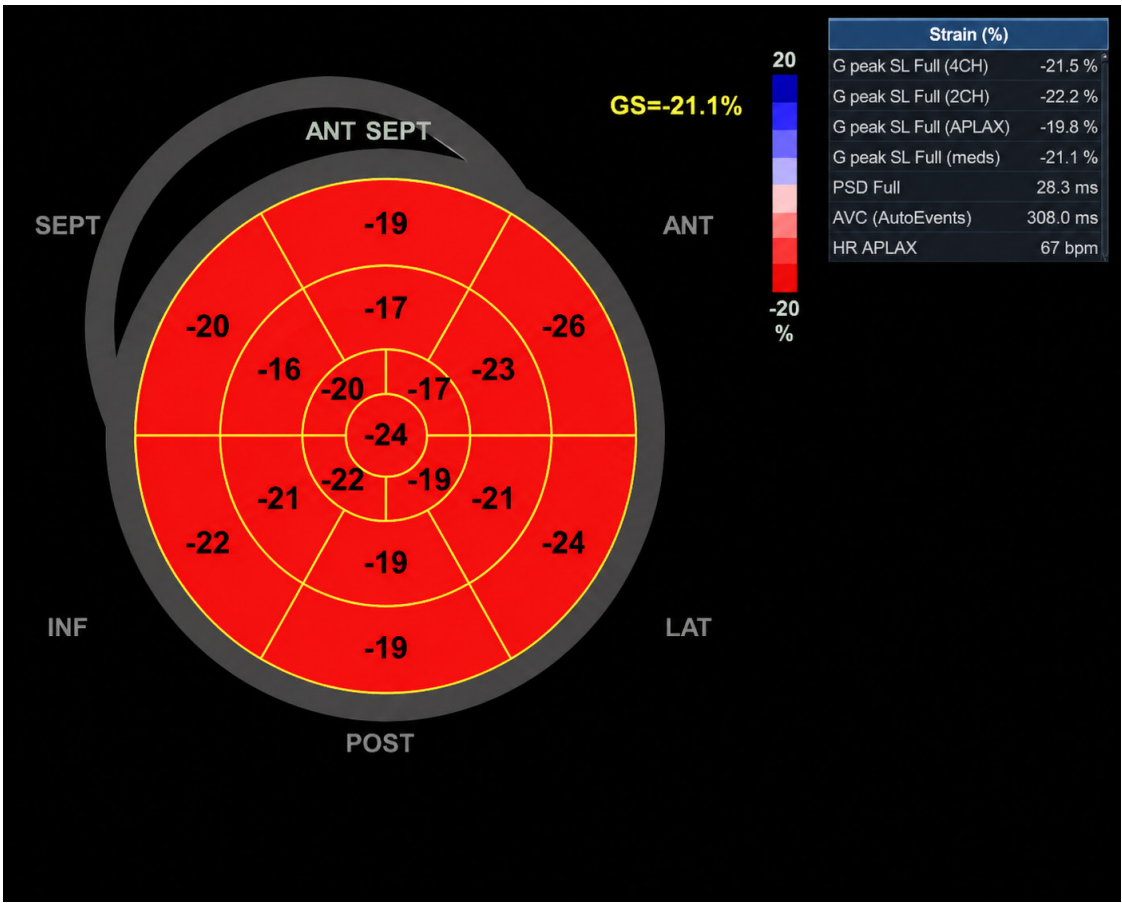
Transthoracic 2D speckle tracking echocardiography showing normal LV strain in patient's daughter with DSP variant. 2D, two-dimensional; DSP, desmoplakin; LV, left ventricular.
